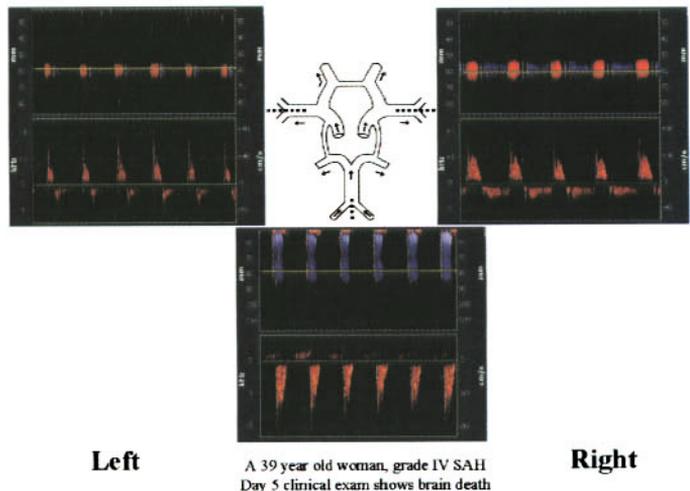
Spectral transcranial Doppler and M-mode findings in both M1 MCA stems and the proximal basilar artery in a patient with clinical examination consistent with brain death.
